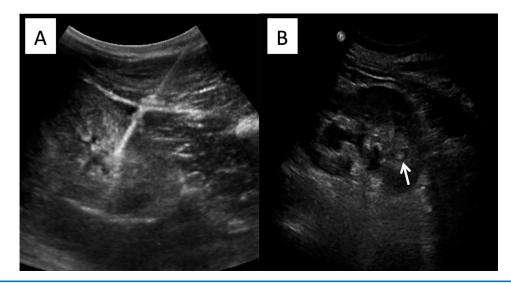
Urinary outlet obstruction caused by bleeding after kidney biopsy. (A) Ultrasound image of a biopsy shows core being obtained in left lower pole. (B) Image 5 days after biopsy when patient reported inability to void. Ultrasound demonstrates hydronephrosis and clot (white arrow) within kidney.
